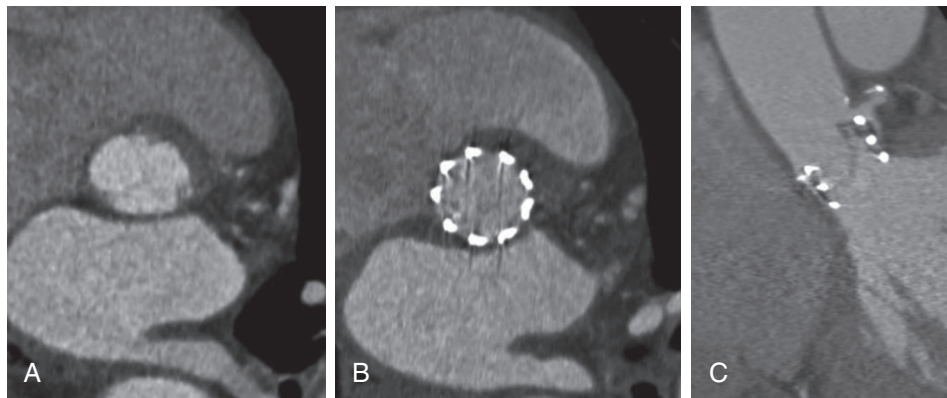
Contrast-enhanced cardiac CT showing the typical appearance of transcatheter aortic valve replacement shown before (A) and after deployment, with short-axis imaging of the expanded metal stent within the aortic annulus (B), and long-axis imaging (C) showing the relationship of the prosthesis to the left main coronary artery. (From Achenbach S, Delgado V, Hausleiter J, et al: SCCT expert consensus document on computed tomography imaging before transcatheter aortic valve implantation (TAVI)/transcatheter aortic valve replacement (TAVR). *J Cardiovasc Comput Tomogr* 6:366, 2012.)
